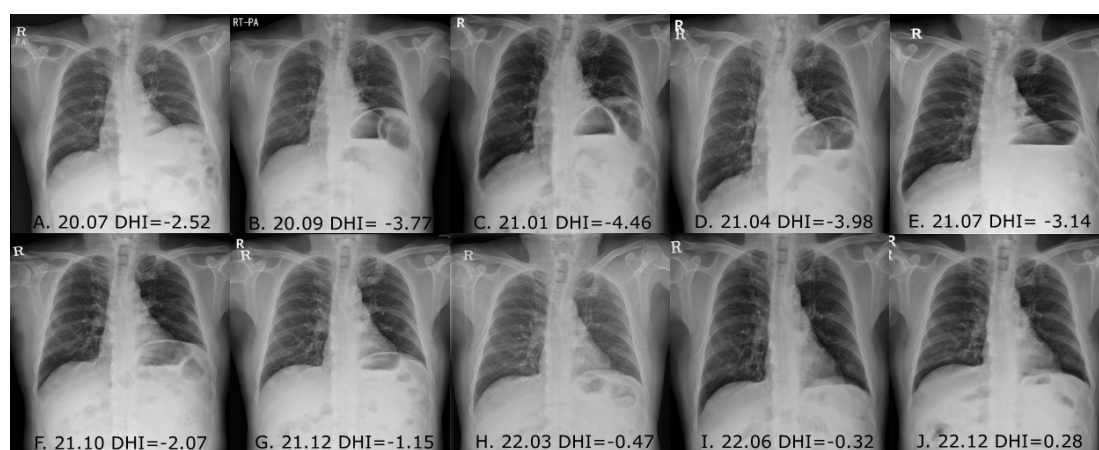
Serial follow-up chest radiographs showing changes in DHI. ($DHI = DHD / VH^3$). The year-month and DHI at each time point are shown in the figure panels. (A-I) The left diaphragm is higher than the right diaphragm. (J) The right diaphragm is higher than the left diaphragm. Normal DHI is $DHI > 0.2$.³
